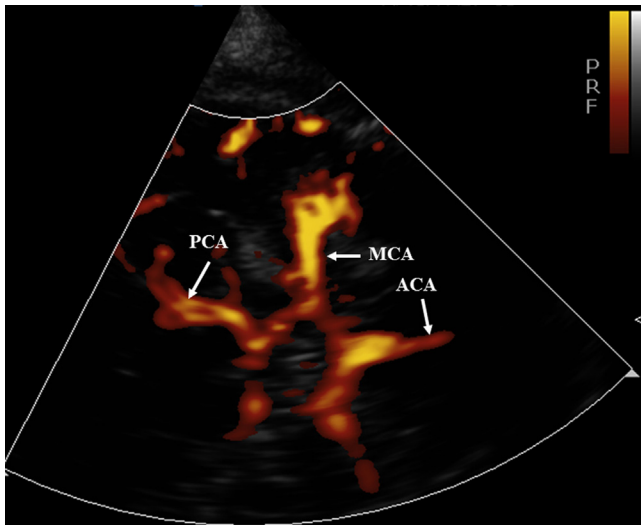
Power Doppler maps of the anterior, posterior and middle cerebral arteries through the temporal bone acoustic window. (ACA=anterior cerebral artery; PCA=posterior cerebral artery; MCA=middle cerebral artery).
